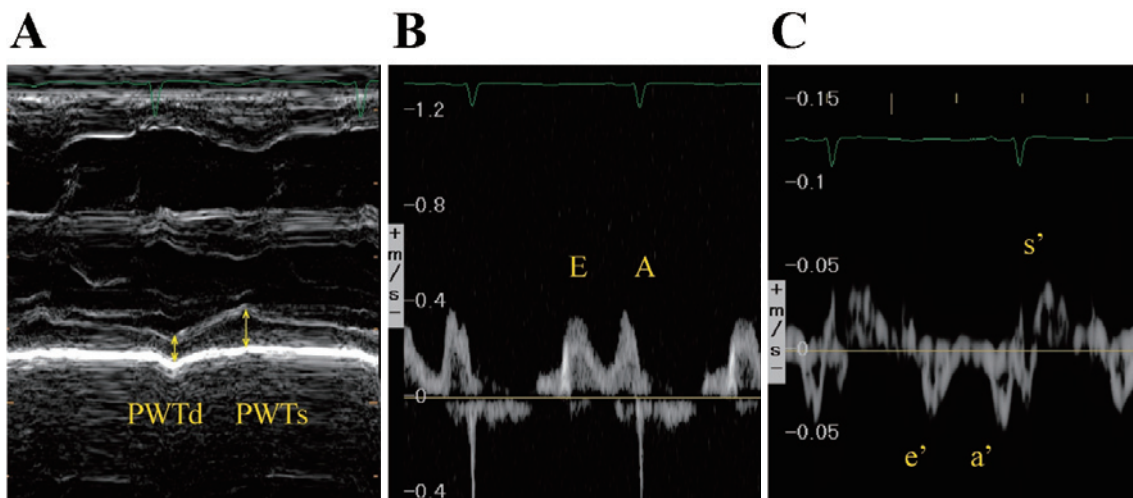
Echocardiographic evaluation of left ventricular diastolic function in a representative 0-day-old neonate. A: Diastolic wall strain (DWS) is calculated from M-mode echocardiography using the following formula: $DWS = (PWTs - PWTd) / PWTs$, where PWTs is posterior wall thickness at end-systole, and PWTd is posterior wall thickness at end-diastole. B: E and A waves of transmitral flow. C: Tissue Doppler imaging of the lateral left ventricular wall.
